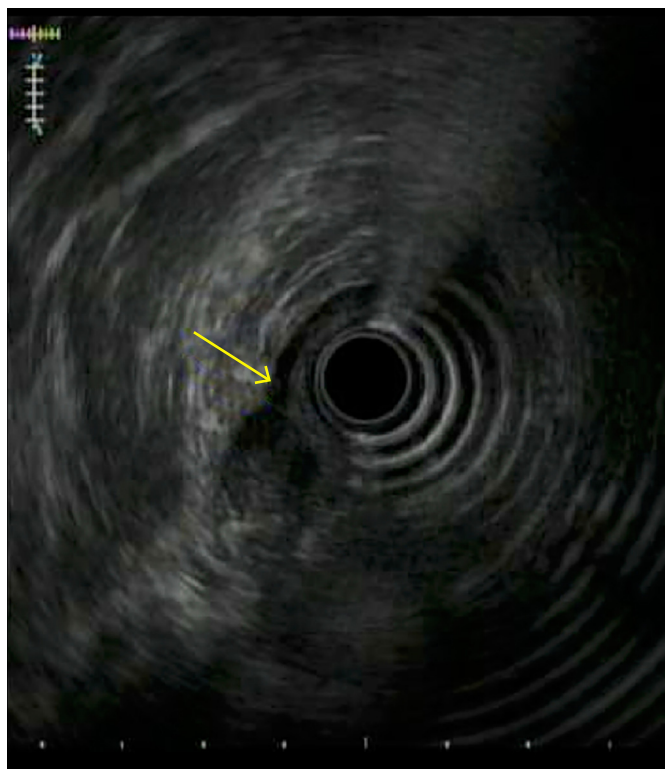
Hypoechoic, ovoid, heterogeneous mass arising from muscularis propria on endoscopic ultrasound.
